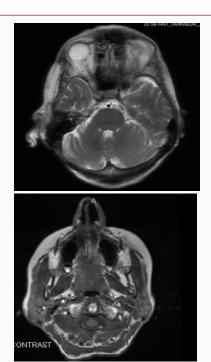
MRI brain internal auditory canal with and without contrast.
